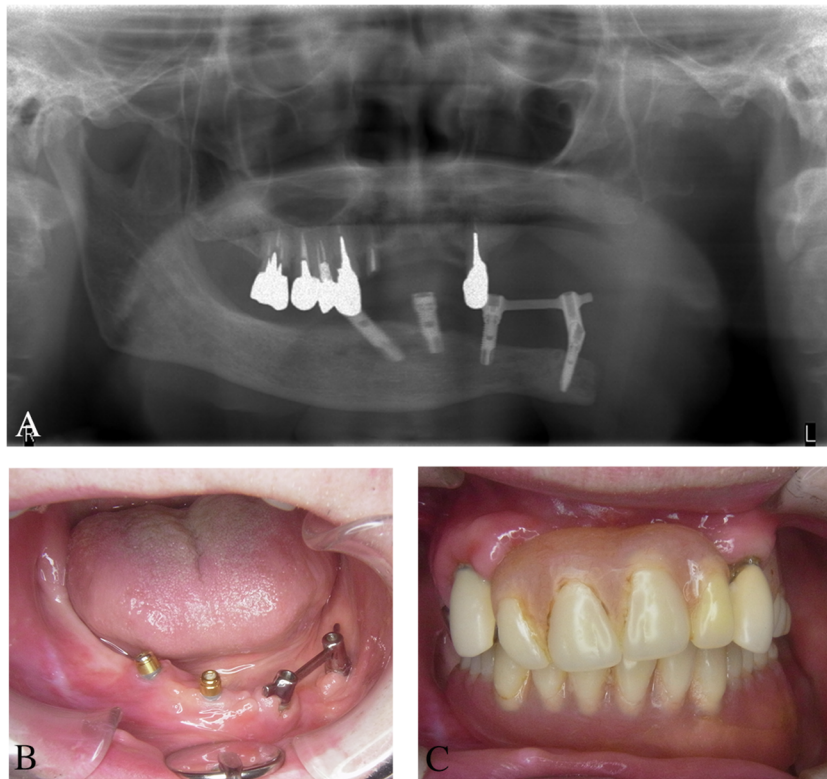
(A) Panoramic X-ray shows 4 dental implants placed in the native and reconstructed mandible. (B) Intraoral photograph shows 2 locator abutments and bar attachment connected to the implants. (C) Intraoral photograph shows the lower denture in place, supported by the implants.
